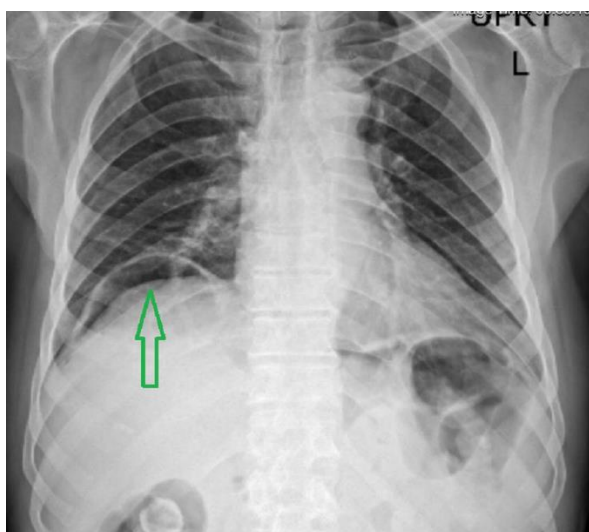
Upright chest X-ray: The green arrow shows the suspicious free air level
